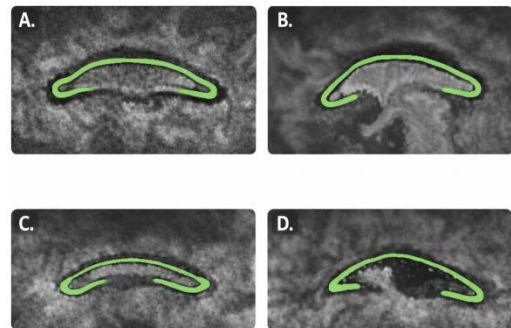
MidCC segmentation success for – A. NACC T1 GRE low resolution/noisy image B. NACC T2 FLAIR image C. ADNI3 Hippocampus high resolution partial brain scan D. UKB patient with partial agenesis
